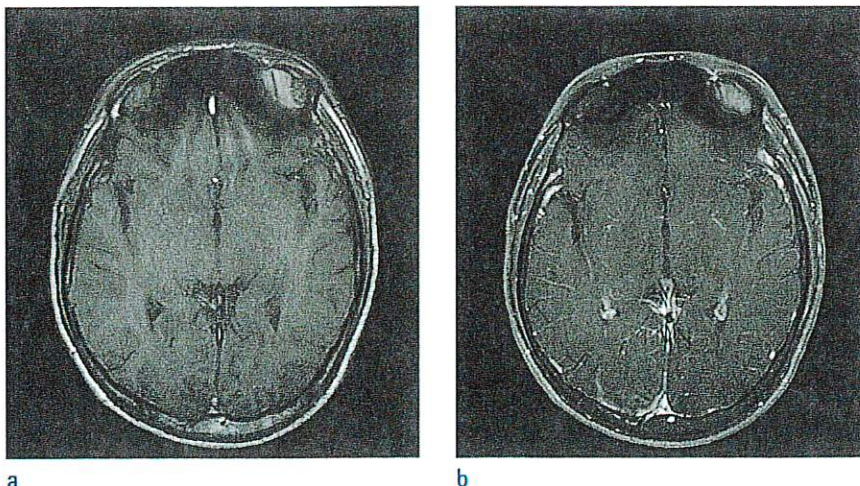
Follow-up MRI (ten days later). (a) Axial T1-weighted MR image shows iso-signal intensity in the bilateral occipital cortices. (b) Axial contrast-enhanced T1-weighted MR image shows irregular enhancement in the bilateral occipital cortices.
